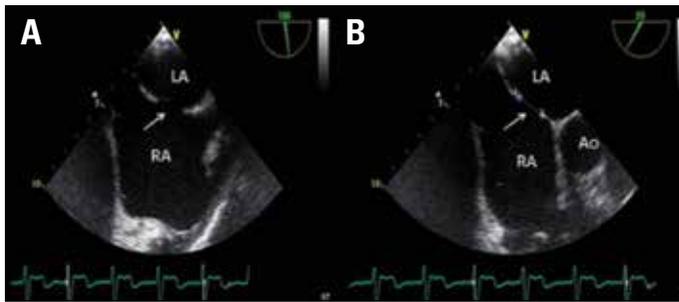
Transesophageal echocardiography images showing secundum atrial septal defect (white arrow) and rims
